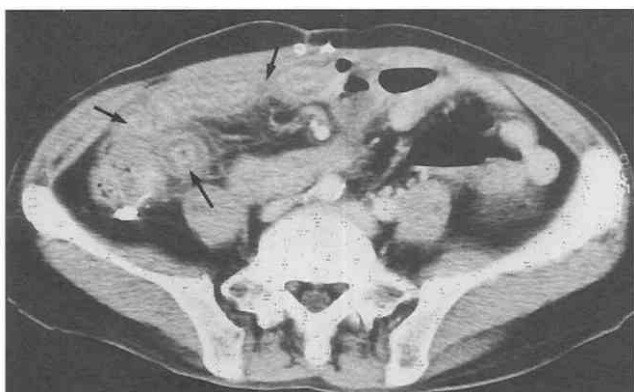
Acute radiation enteritis in a patient with a history of radiation therapy for periureteral metastases from rectal cancer. CT scan shows bowel wall thickening (*arrows*) of the ileal loops, with the target appearance confined to the radiation port. (From Rha SE, Ha HK, Lee SH, et al: CT and MR imaging findings of bowel ischemia according to the various primary causes. *Radiographics* 20:29-42, 2000.)
